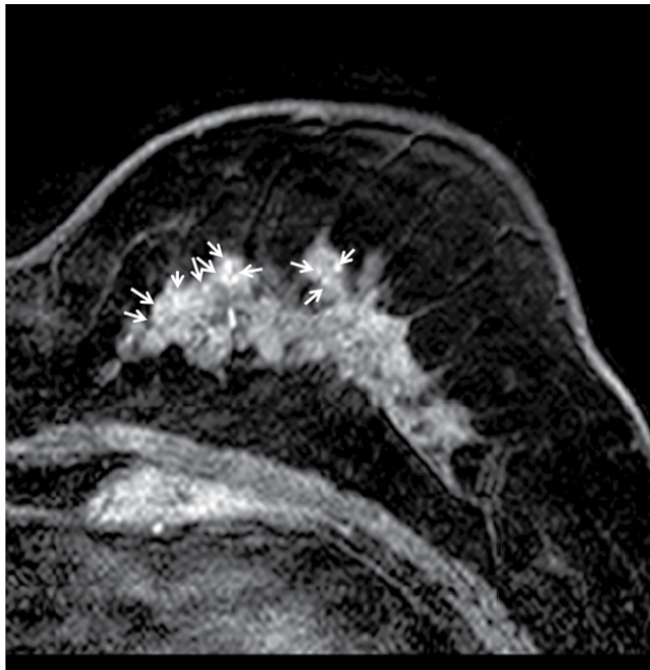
Non-contrast enhanced T1 weighted image of HR-MRI; Multiple dot-like high signal intensities are seen on the mass (arrows). These high signal intensities might reflect the secretory material of the secretory carcinoma.
